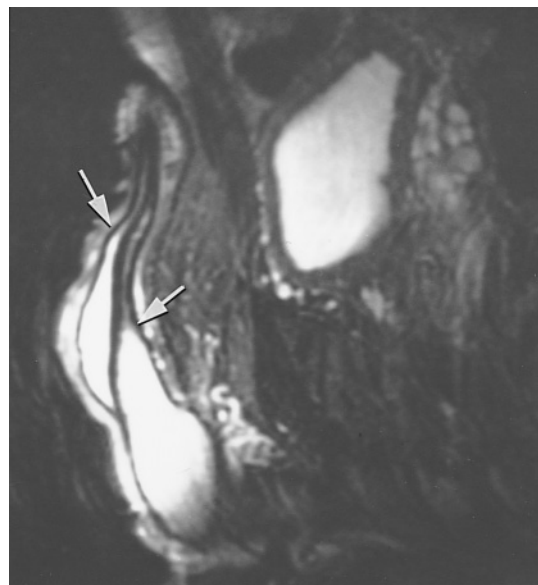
Partial aplasia of the corpora cavernosa and spongiosum. Sagittal T2-weighted ETSE image. The distal aspects of the corpora cavernosa and spongiosa are atrophic and demonstrate a dramatic change in caliber (arrows) in this patient presenting with distal erectile dysfunction. The patient had other concomitant urogenital anomalies.
